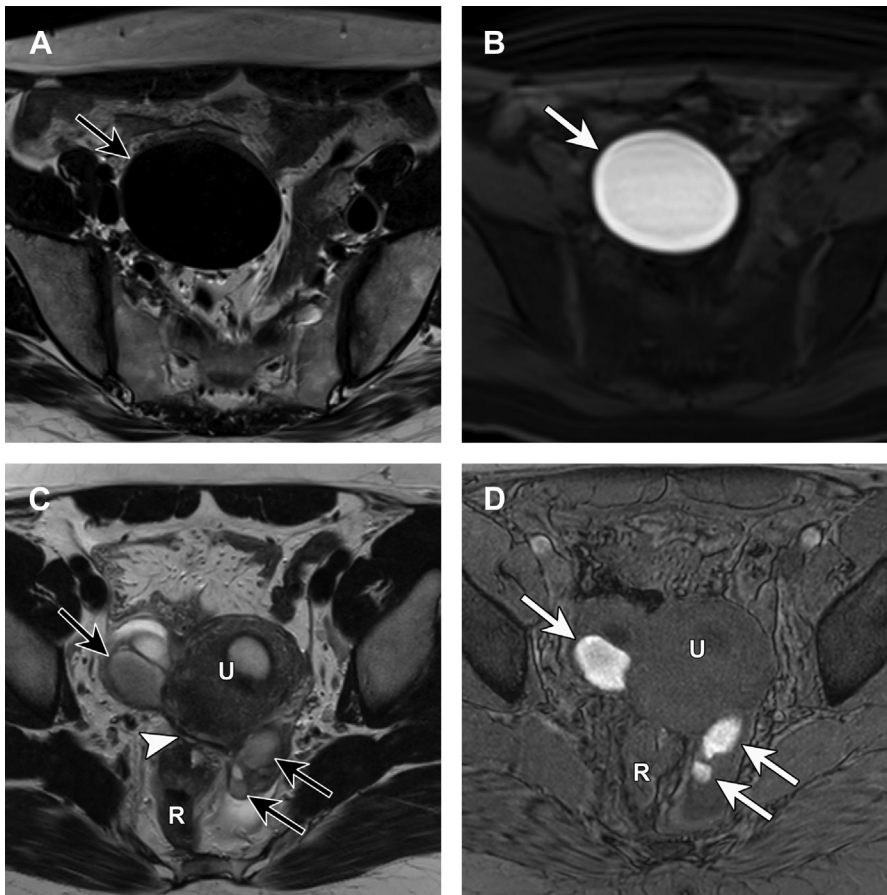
Examples of endometriomas with variable T2 shading in two patients (A and B vs C and D). T2-weighted axial MR images (A, C) show endometriomas with T2-weighted hypointensity consistent with T2 shading (black arrows). T1-weighted axial MR images with fat saturation (B, D) showing corresponding marked homogenous hyperintense signal (white arrows). (C) and (D) Multiple endometriomas in both ovaries. The axial T2-weighted image (C) also shows a hypointense fibrotic deposit of deep infiltrating endometriosis between the ovaries overlying the posterior uterus (white arrowhead). U, uterus; R, rectum.
